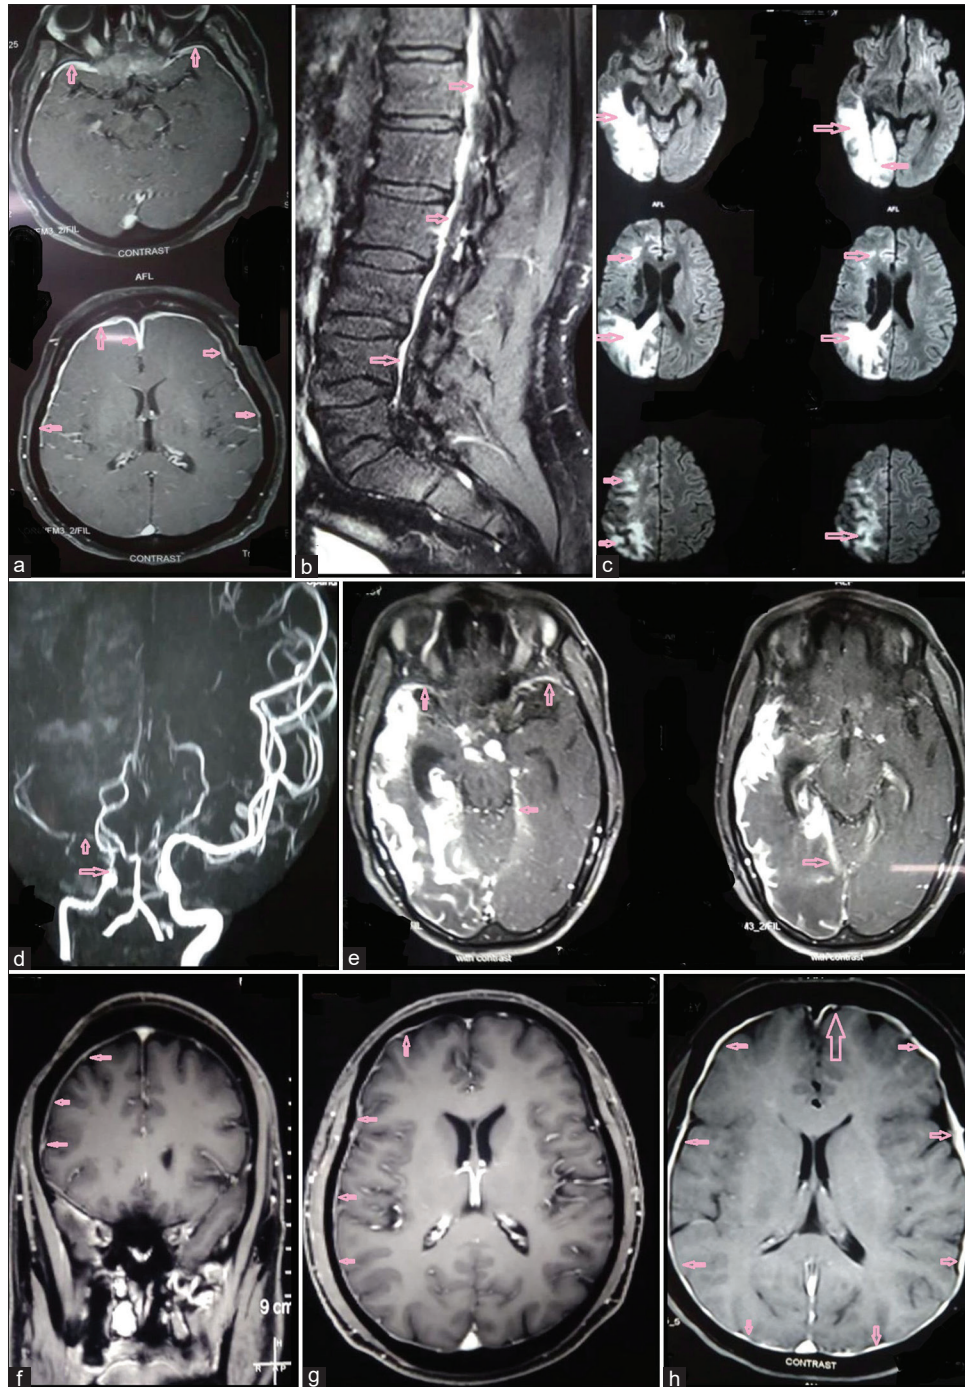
Idiopathic HP, “other infections” associated HP, spinal HP, complications of HP. (a) T1 contrast image: patient with idiopathic HP having bilateral enhancements in frontal, parietal, and temporal regions (marked with pink arrows) (b) T1 contrast image: patient with TB having dorsolumbar HP (marked with pink arrows) (c) DWI image (d) MR angiography, (e) T1 contrast image: patient with TB HP with arteriopathies having diffusion restrictions in the right frontal, parietal, temporal, and occipital lobes. The caliber of right ICA and MCA are reduced, along with focal arteriopathy in the right posterior cerebral artery. There is contrast uptake in subacute infarcted tissues, and there are focal pachymeningeal enhancements of bilateral anterior temporal, and tentorium cerebelli regions (marked with pink arrows) (f) T1 contrast axial image (g) T1 contrast coronal image: patient with right parietal bone osteomyelitis (post-debridement status), with underlying pachymeningeal enhancements (marked with pink arrows) (h) T1 contrast image: patient with idiopathic HP having bilateral enhancements in frontal, parietal temporal, and occipital regions (marked with pink arrows)
